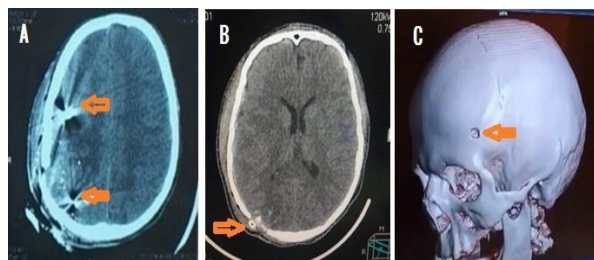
Brain CT scan findings. A) brain window axial CT scan shows tract hematoma and metallic shadow of bullet (red arrow), B) brain window axial CT scan shows the entry point of bullet where it settled near the skull bone (red arrow), and C) 3D skull bone CT scan reconstruction shows site of entry of bullet.
